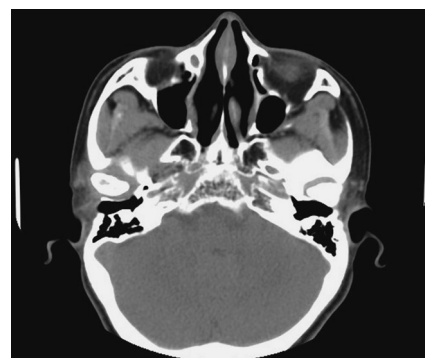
The transverse view of computed tomography showing a small radiolucent lesion adjacent to the right condyle.
